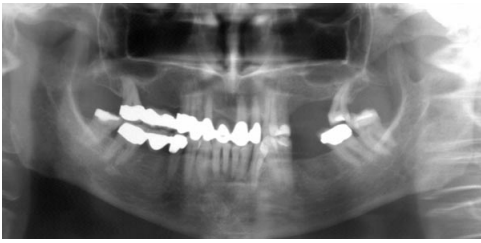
Orthopantomogram of a 56-year-old patient with an atrophy of the left maxilla
